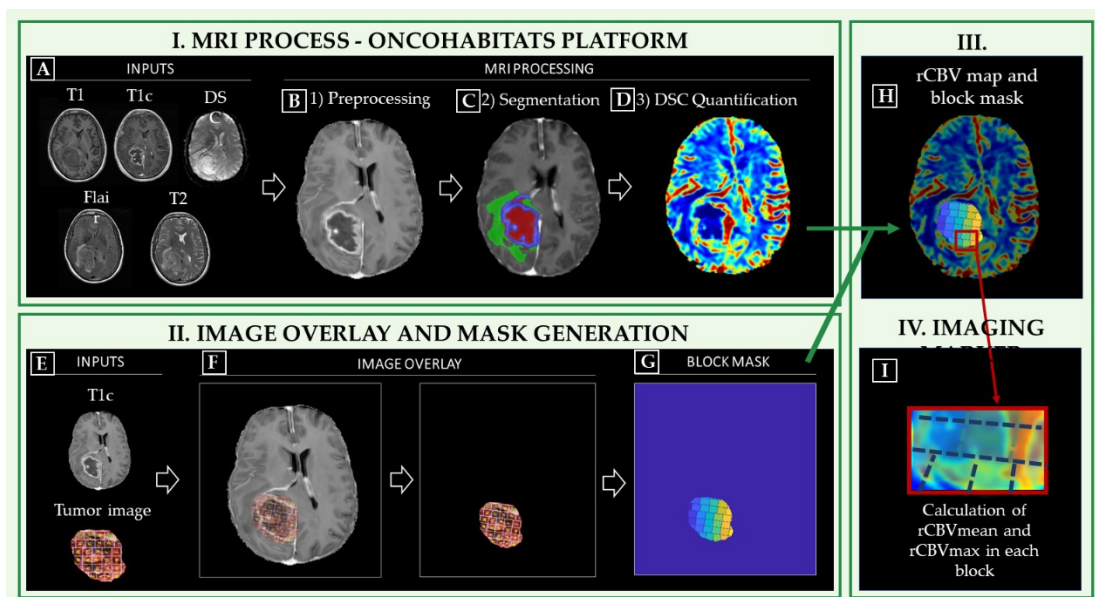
Stages of methodology: I) MRI Process conducted by the Segmentation Service included in the ONCOhabitats platform; II) Image overlay and mask generation; III) Coregistration and IV) Calculation of imaging markers. A) Required inputs for the MRI process (T1, T1c, T2, Flair and DSC); B) Preprocessing of the MRIs; C) Classic segmentation of the lesion into tumor, edema and necrosis; D) DSC perfusion quantification and rCBV map calculation. E) Inputs to generate the block mask; F) Image overlay process for mask generation; G) Block mask; H) Overlay of the rCBV map and block mask; I) Calculation of imaging markers ($rCBV_{\text{mean}}$ and $rCBV_{\text{max}}$) in each tissue block.
